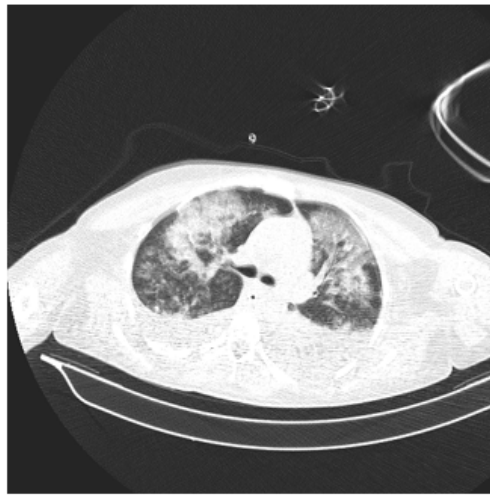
Case 2: Thorax CT.
